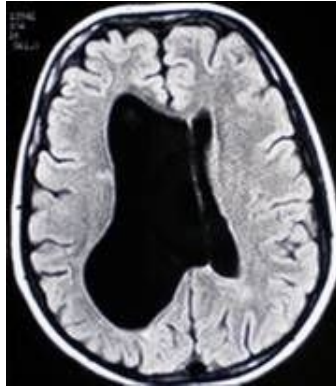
Brain MRI 1 year after the operation
